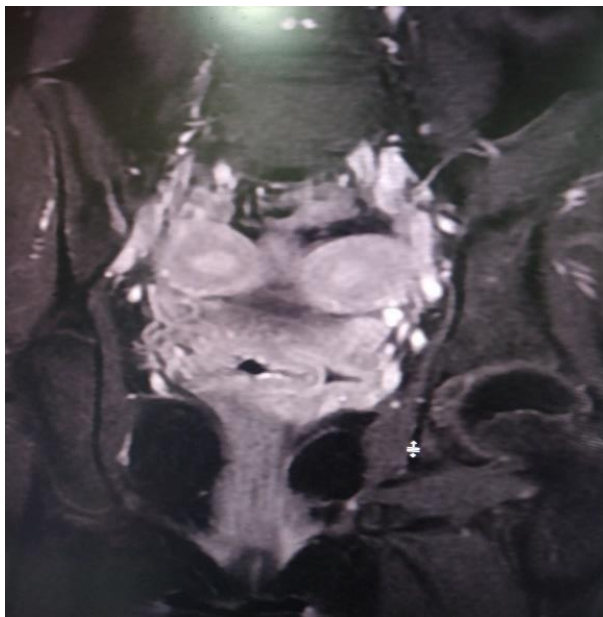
Post operative MRI showing didelphys uterus without any gross distension.
